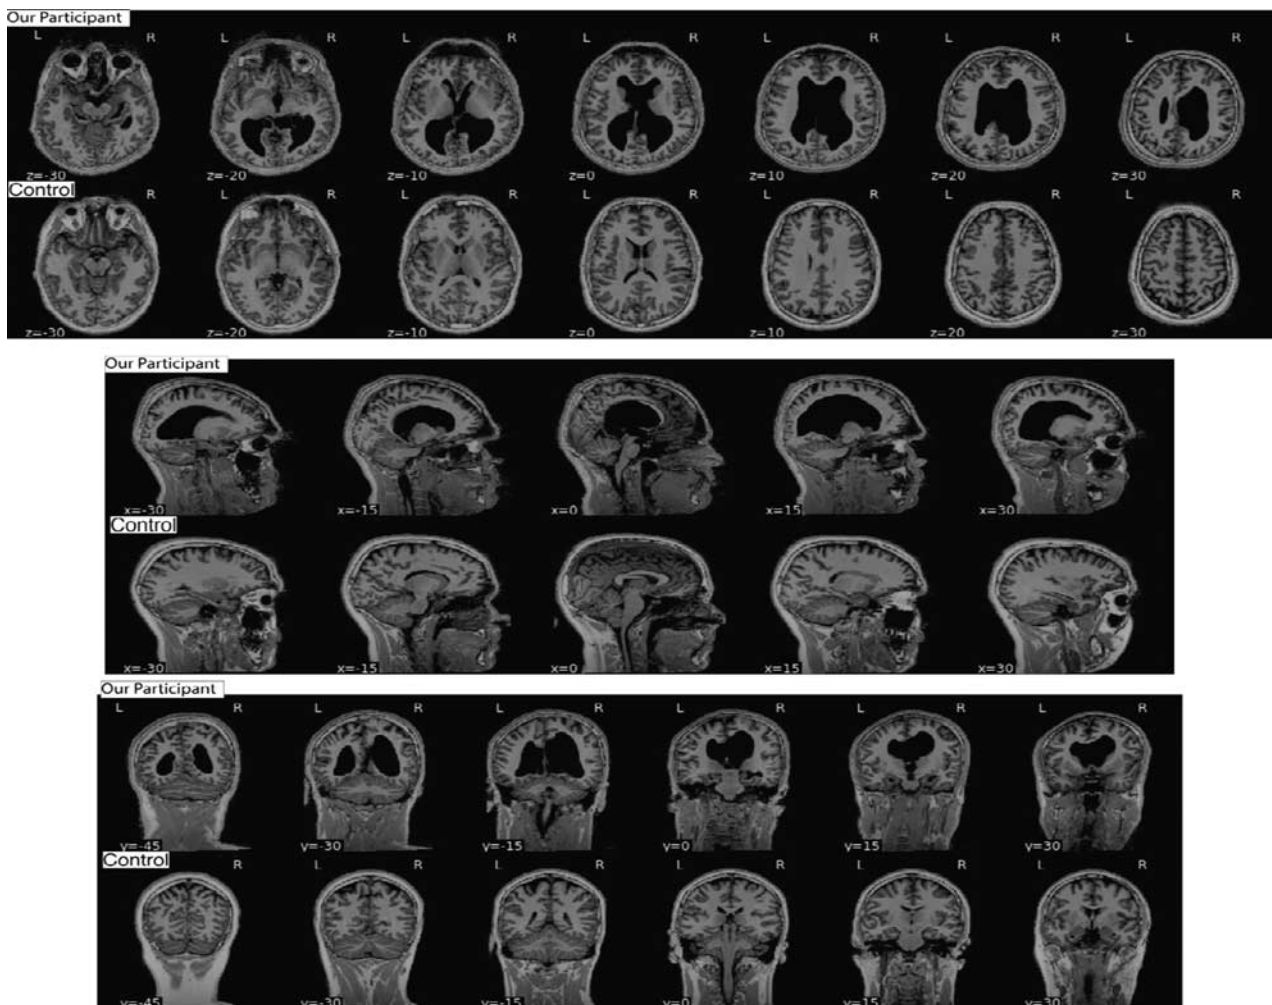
MRI of our participant and of an age-matched control. L = left. R = right.
